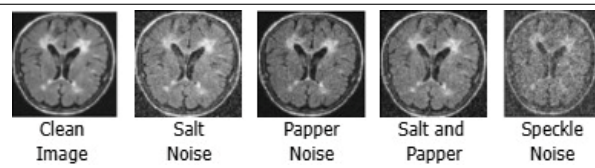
Sample of noise types artificially induced on brain Magnetic Resonance Imaging (MRI) images.
